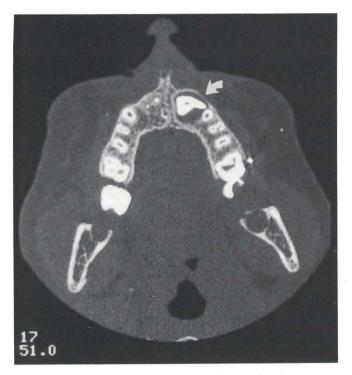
Axial CT scan demonstrates the distal inclination of the crown of tooth #21. No root can be seen.
